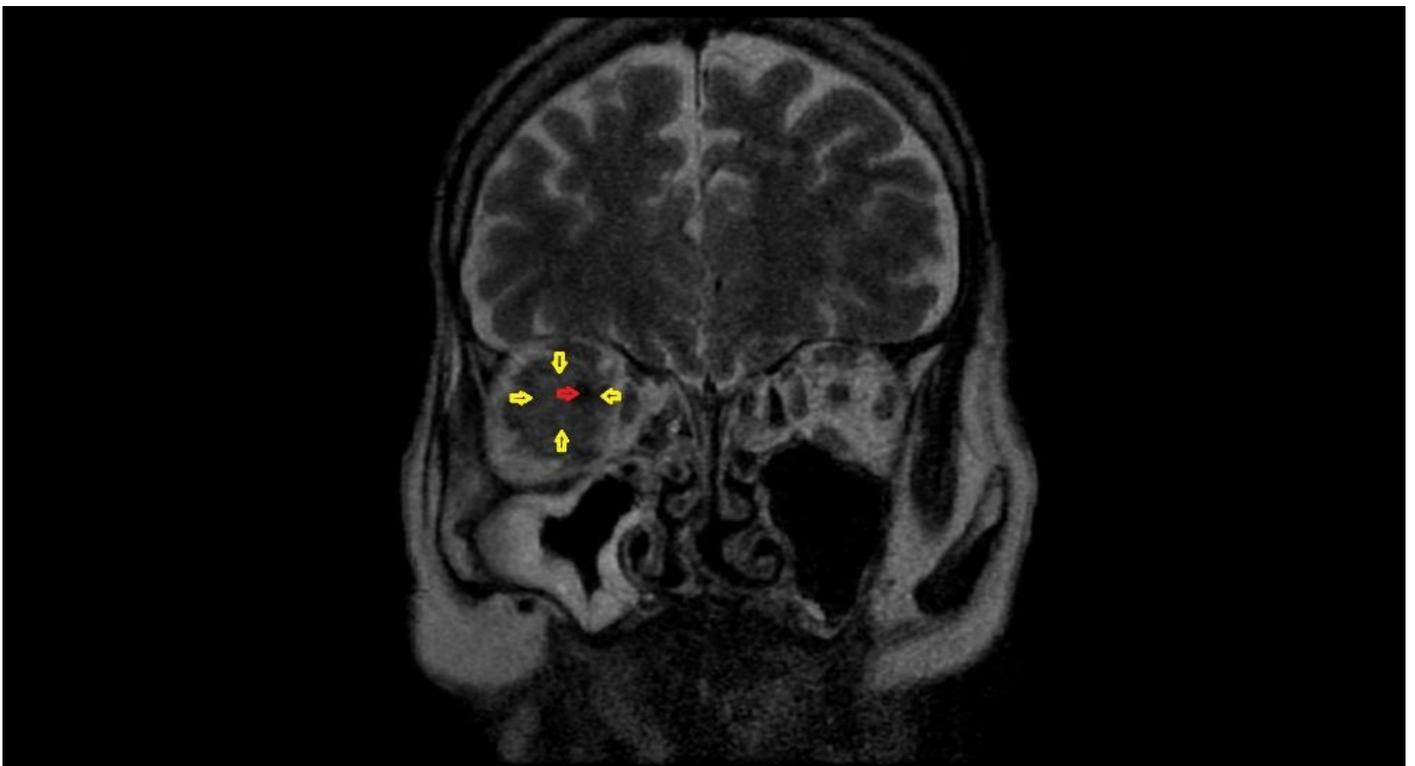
The coronal T2 MRI scan of optic nerve sheath meningioma (yellow arrow) and optic nerve (red arrow)
